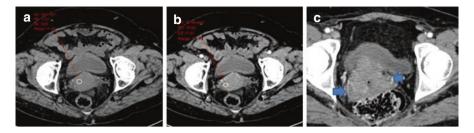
Axial images in CT in single phase (a) and contrast phase (b) in the same patient, the cervix is enlarged whithout enhancement; other patient (c) with a tumor larger and with heterogeneous enhancement, the arrows point the tumor with parametrial extension
